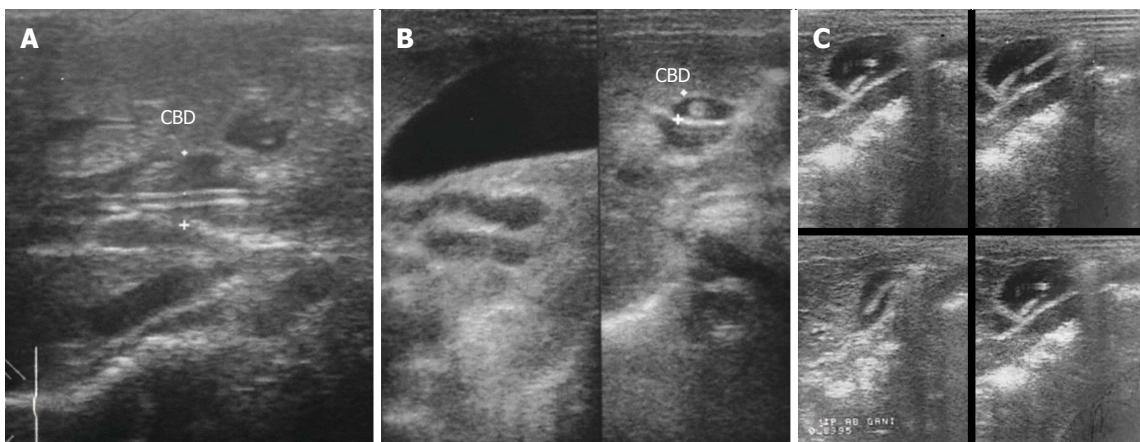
Ultrasonography images in hepatobiliary and pancreatic ascariasis. A: Biliary ultrasound depicting four-line sign; B: Ultrasound showing tube like structure within common bile duct with distended gall bladder; C: Ascarides in gall bladder showing active movements as seen in serial images. Adapted from Khuroo^[5].
